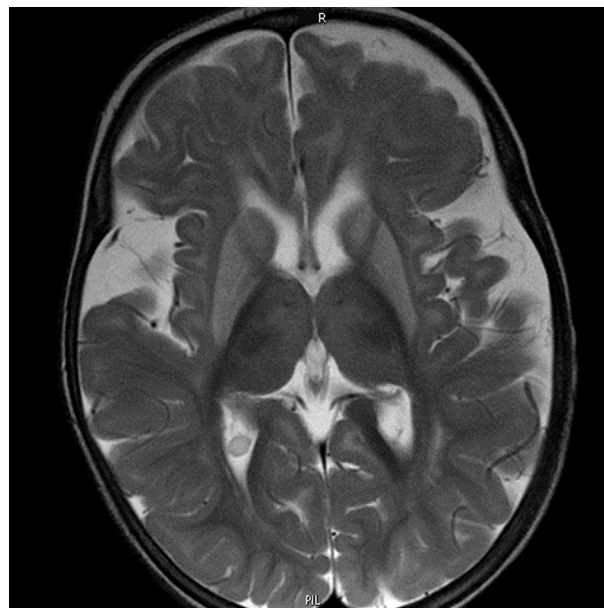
T2 axial view of MRI of brain showing bilateral symmetric hyperintense signals in the basal ganglia.
